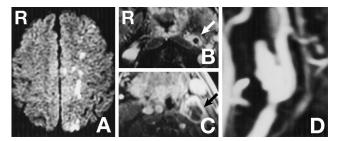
A: Diffusion-weighted magnetic resonance (MR) image obtained after the manifestation of hemiparesis and motor aphasia showing multiple hyperintense lesions suggesting border zone infarction between the territories of the anterior and middle cerebral arteries. B, C: T_1 -weighted MR images with contrast medium showing marked enhancement of the internal carotid artery (ICA) wall (B, arrow) and pseudoaneurysm wall (C, arrow). D: MR angiogram demonstrating occlusion of the ICA distal to the aneurysm, and patent flow to the aneurysm and external carotid artery.
